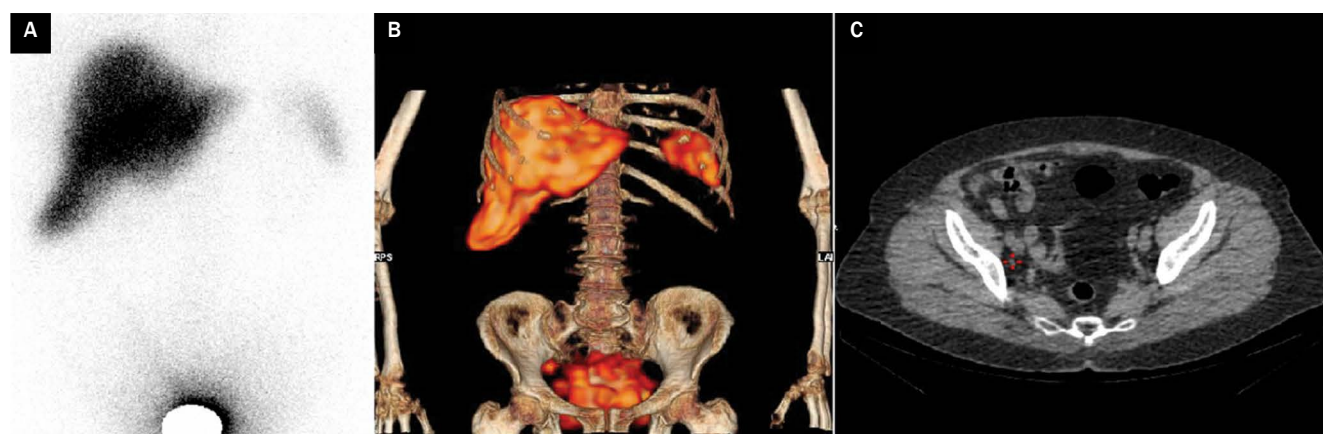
Planar lymphoscintigraphy (PL) and SPECT/CT in a 67-year-old patient with grade 2 endometrial adenocarcinoma; PL (A) did not show activity corresponding to a SLN. The fused SPECT/CT image (B) showed a focal accumulation in the right hemipelvic region, corresponding to two, non-enlarged lymph nodes in the right internal iliac region at the CT (C)
